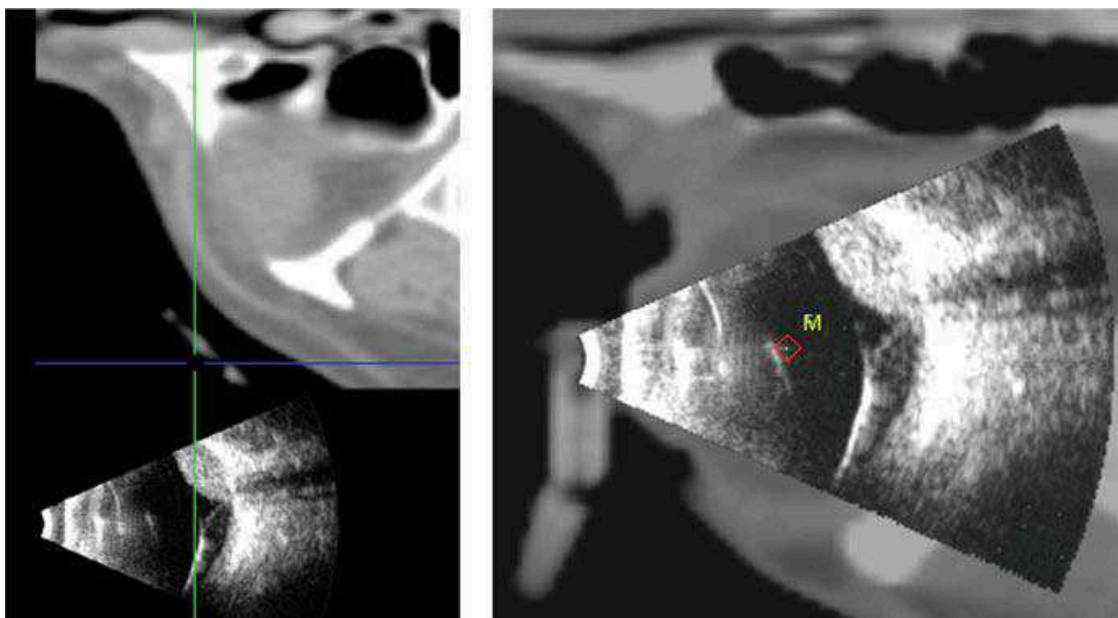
Landmark-based registration results for three patients. Ultrasound is superposed to the CT image. Moving landmarks are in yellow, fixed landmarks are in cyan. The lens mask in blue and the eyeball contour in black. (Top row) Patient 1: Axial (*left*) and coronal (*right*) views of superposition. Landmarks are in the back of the lens (0), and in tumors (1 and 2). (Middle row) Patient 2: Axial (*left*) and sagittal (*right*) views of superposition. Landmarks are in the back of the lens (0), head of the optic nerve (1) and center of the eye ball (2). (Bottom row) Patient 3: Axial (*left*) and sagittal (*right*) views of superposition. Landmarks are in the head of the optic nerve (0), back of the lens (1) and small calcified tumor (2)
